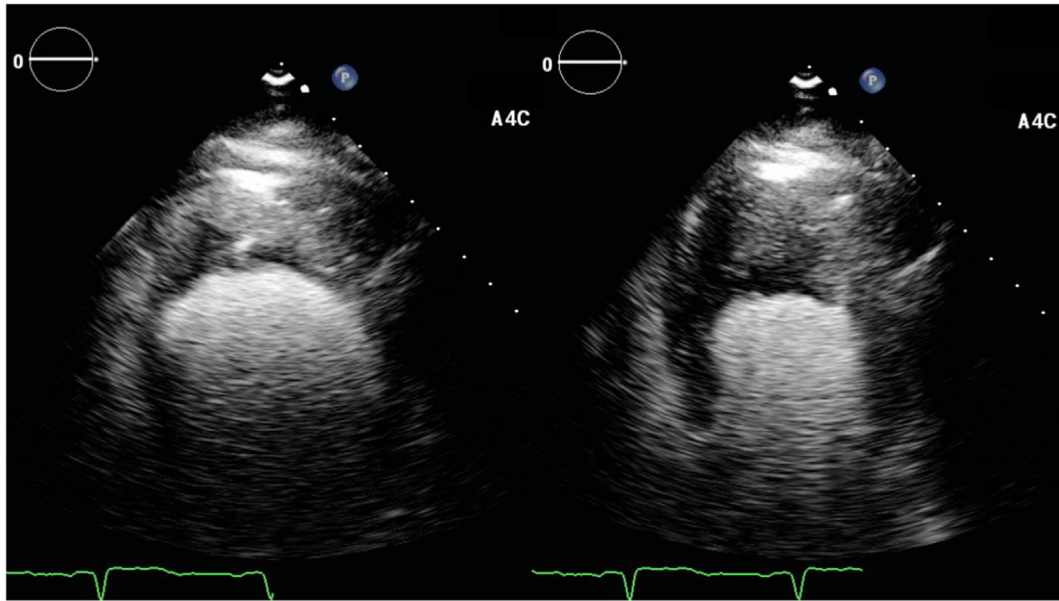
Transthoracic echocardiogram apical 4-chamber view in end diastole (*left*) and end systole (*right*) using an ultrasound-enhancing agent demonstrates echodense material in the LV apex, contiguous with the LV endocardium.
